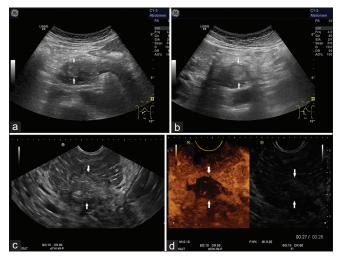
56-year-old male. Focal fatty replacement. History of acute pancreatitis, continued alcohol abuse. Ultrasonography shows a focal hyperechoic area in the pancreatic head (a and b). On endosonography, this is irregularly delineated (c). In CELMI-EUS with 4.8 mL SonoVue the area is not enhanced (d). CELMI-EUS: Contrast-enhanced low mechanical index-EUS
